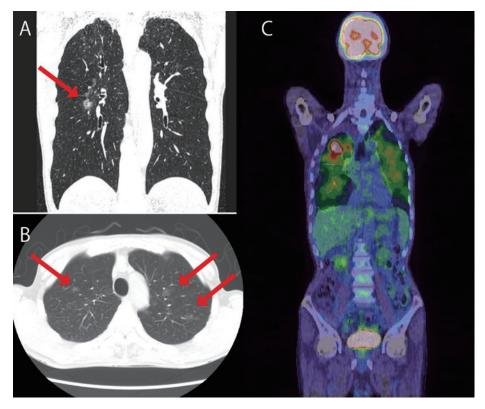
Chest computed tomography (CT) imaging and positron emission tomography (PET)-CT scan. (A) Coronal plane. A solid lesion (arrow) was present in the right lower lobe (S6). (B) Transverse plane. Patchy ground-glass opacities were observed (arrow). (C) PET-CT scan performed after right partial lobectomy. Abnormal uptake of fluorodeoxyglucose was detected only in the bilateral lungs.
